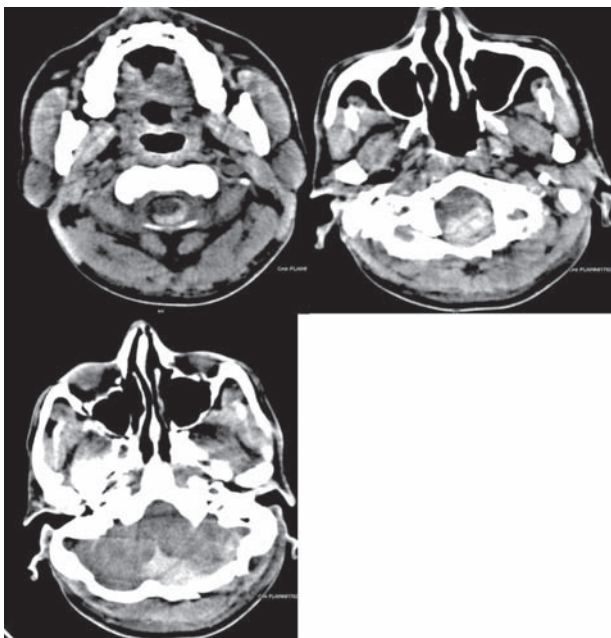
CT scan of head and cervical spine 3 days following trauma revealed posterior fossa extradural and subdural hematoma and cervical extradural hematoma.
